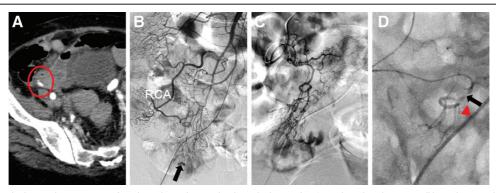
An 82-y-old terminal stage breast cancer female patient who received surgical resection 3 weeks prior, due to small bowel strangulation. A, Multidetector computed tomography demonstrated contrast extravasation into the distal ileum (circle). B, Superior mesenteric artery angiogram showed active bleeding in the distal ileum (arrow). C, The bleeding artery was from one torturous branch of the right colic artery (RCA) with difficulty to reach the bleeding vasa rectum. D, The microcatheter tip (arrow) was left in the marginal artery for vasospasm therapy by bolus injection of 0.4 mg epinephrine and followed by 4 units/h vasopressin infusion for 5 h. Arrowhead: bleeding vasa rectum. No recurrent bleeding at 2-mo clinical follow-up.
